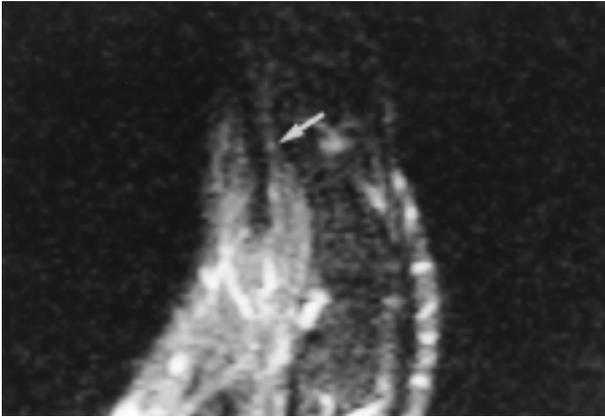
MRI appearance. High-intensity (bright) signal around the nail bed, indicating increased blood flow. The arrow points at the site of the glomus tumor.
